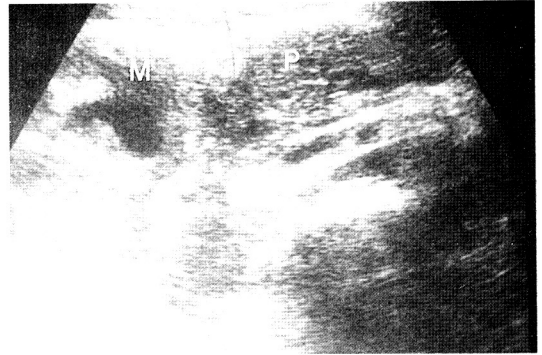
Abdominal ultrasonography(midline transverse section) shows a 5.7X4.2X4cm sized, central anechoic mass lesion(indicated with a letter 'M') on the right side of the pancreas head(indicated with a letter 'P')
